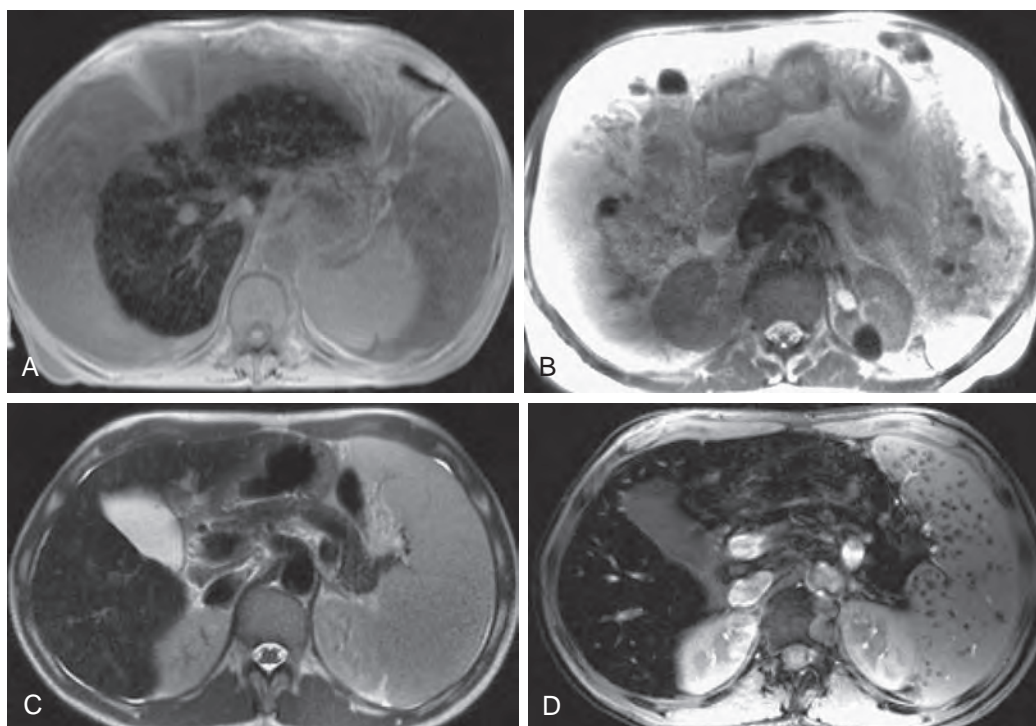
Hemochromatosis: MR findings. Two different patients with hemochromatosis. A. MR scan shows a cirrhotic, markedly hypointense liver surrounded by ascites. The spleen is spared because it is composed primarily of reticuloendothelial cells, which do not accumulate iron in hemochromatosis, an important differentiating feature from hemosiderosis. B. Scan obtained caudal to A shows low signal intensity of the pancreas; the acinar cells do accumulate iron. In a different patient, T1-weighted (C) gradient-echo (D) images of the upper abdomen show marked hypointensity of the liver and spleen due to the deposition of iron in the hepatocytes of the liver and the acinar cells of the pancreas. Notice the low signal intensity Gamna-Gandy bodies in the spleen, secondary to hemosiderin deposition, a finding seen in portal hypertension with microhemorrhages into the splenic parenchyma.
